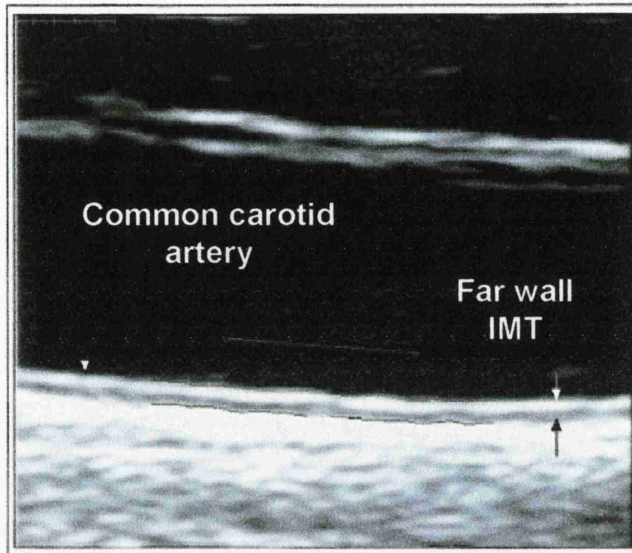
B-mode ultrasound of the common carotid artery
